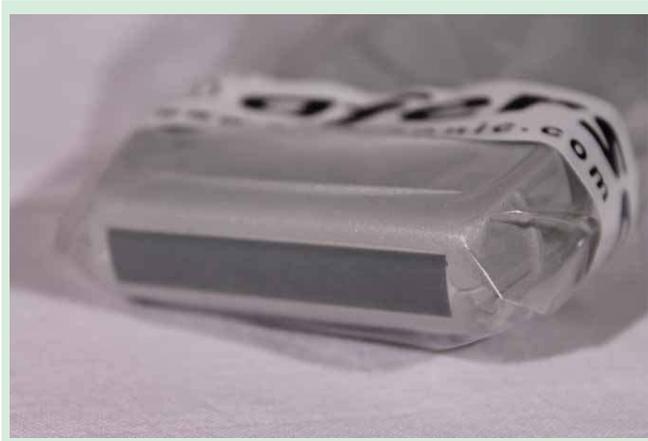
The ultrasound probe prepared in a sterile manner.
